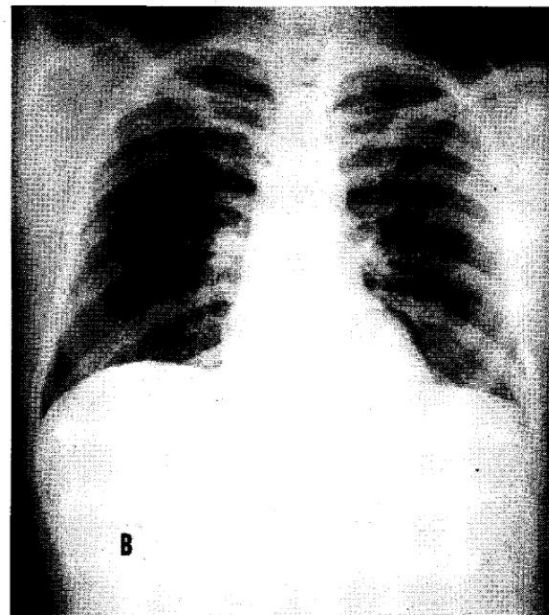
B, X-rays on Aug 11, 1961, after eight months of bed rest. He has since returned to work and remains asymptomatic.
